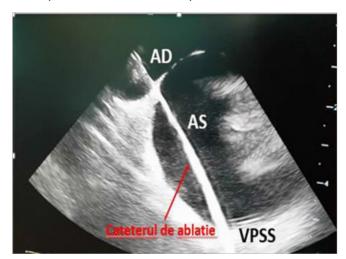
Intracardiac echocardiography during pulmonary vein isolation. The ablation catheter is situated inside the left superior pulmonary vein. It passes through the interatrial septum at the level of fossa ovalis.
